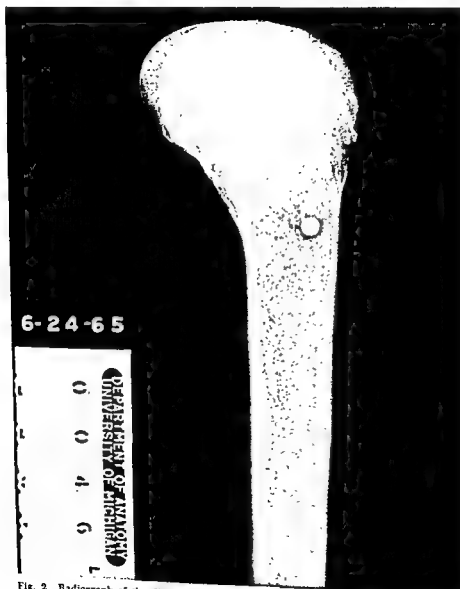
Radiograph of the distal femur showing a one-fourth inch steel sphere imbedded in the bone. Impact velocity was 483 ft/sec. The projectile entered the bone from the left.
